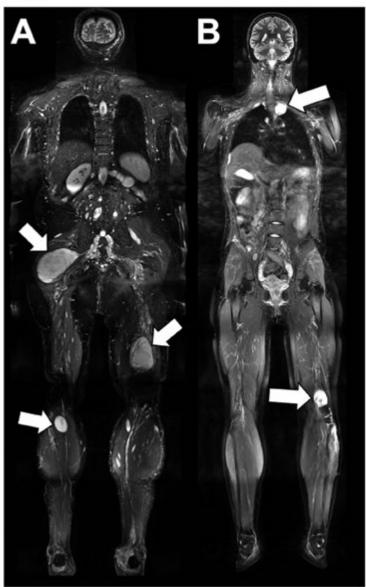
Images of coronal T2-weighted, fat-saturated magnetic resonance imaging sequences of two patients acquired at 3T:
